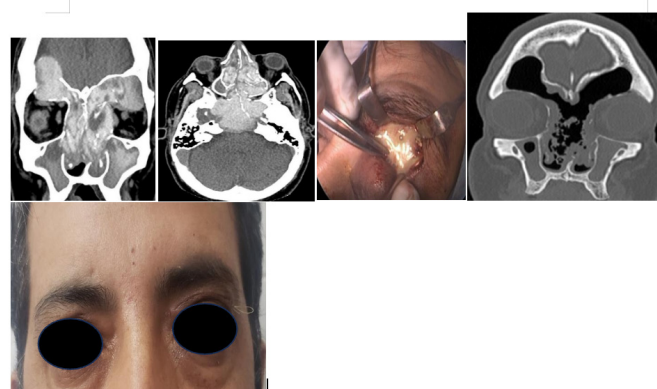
Allergic fungal rhinosinusitis. A: coronal CT showing bone erosion of the right frontal roof and floor, extradural intracranial extension of the allergic mucin, and left orbital involvement with abscess; B: axial slice showing extensive bone erosion of the skull base; C: drainage of the orbital abscess via a superior palpebral approach; D: immediate postoperative CT; E: intradermal suture of the bipalpebral incision, 7 days after surgery.
